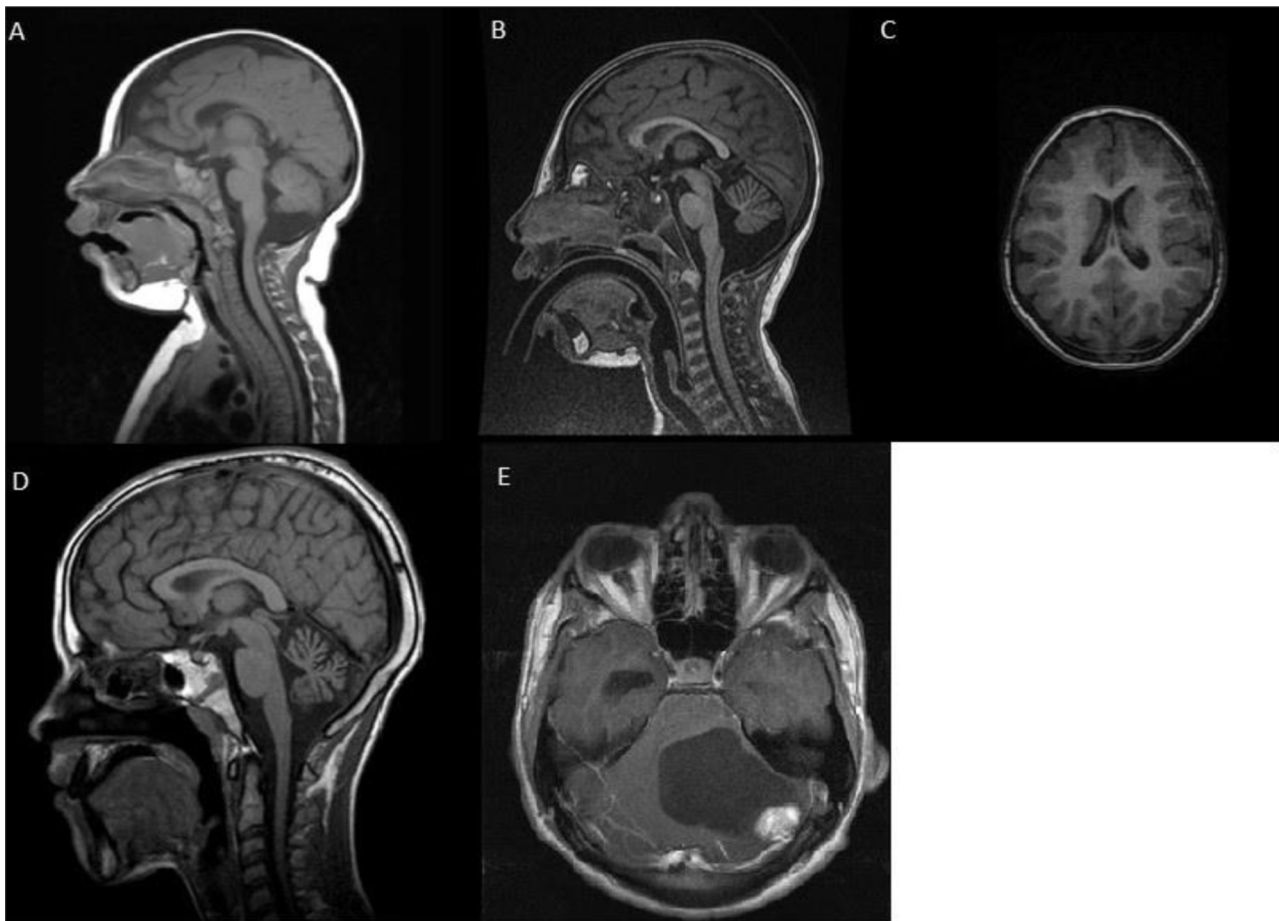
Representative magnetic resonance images. (A and B) Sagittal T1 of Patient 4 at five months (A) and three years (B) showing the development of cerebellar atrophy. (C) Transversal T1 of Patient 4 at three years showing microcephaly with a simplified gyral pattern. (D) Sagittal T1 of Patient 8 at 13 years showing cerebellar atrophy. (E) Transversal T1 of Patient 6 at 17 years showing a cerebellar hemangioblastoma.
